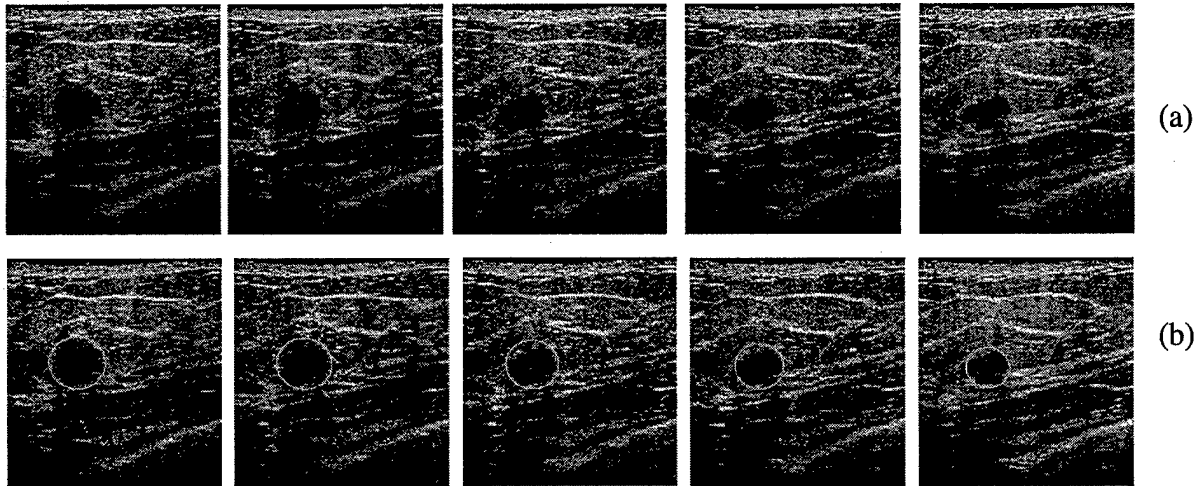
(a) Five consecutive slices of one of the 3D ultrasound cases in our data set. (b) The initial ellipsoid defined by an experienced radiologist.
